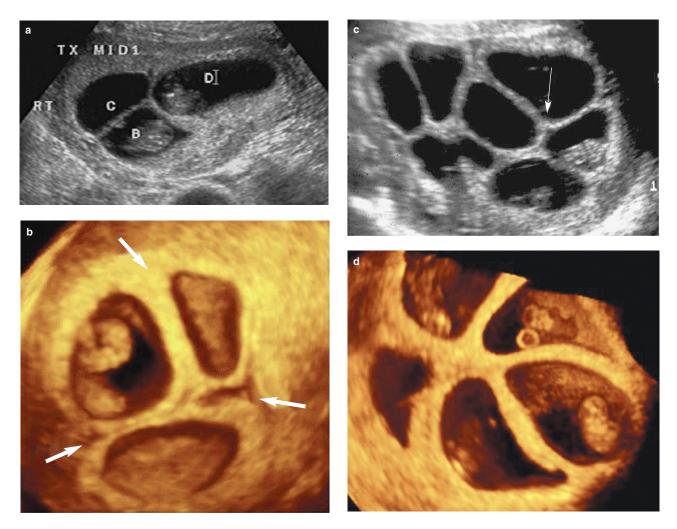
Determining chorionicity. (a) A trichorionic gestation at 8 postmenstrual weeks. Note the 'Y' sign at the meeting point of the three chorionic sacs (long arrow) and the delta ('twin peak') signs (short arrows) between two adjacent chorionic sacs. (b) A three-dimensional ultrasound rendering of an 8.5-week trichorionic–triamniotic triplet pregnancy. The arrows point to the triangular 'delta' or 'twin peak' signs. In one of the sacs the amnion is visible (small arrow). (c) This is a multichorionic and multiamniotic multifetal pregnancy. Each of the 12 live fetuses had its own chorion, amnion and tiny placenta. On the plane of this image, however, only eight could be included. The arrow points to one of the many 'Y' shared junctions created by three adjacent chorions. (d) A three-dimensional rendering of a quintuplet pregnancy with five chorions and five amnions (7 postmenstrual weeks)
